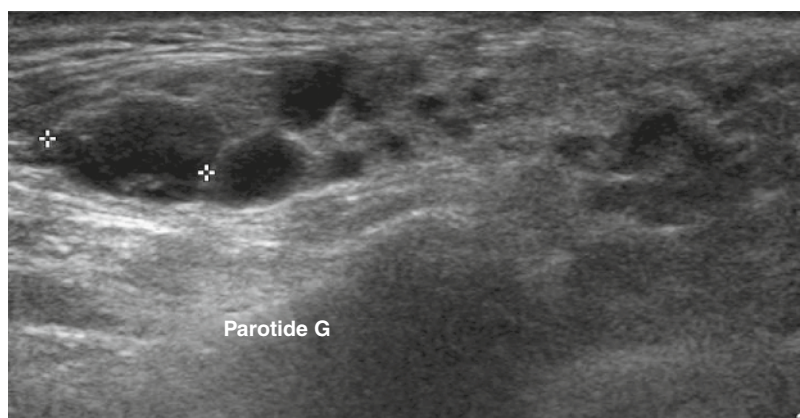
The transverse ultrasound image of a parotid gland shows the heterogeneous aspect of the gland with many anechoic structures, which are cysts.
